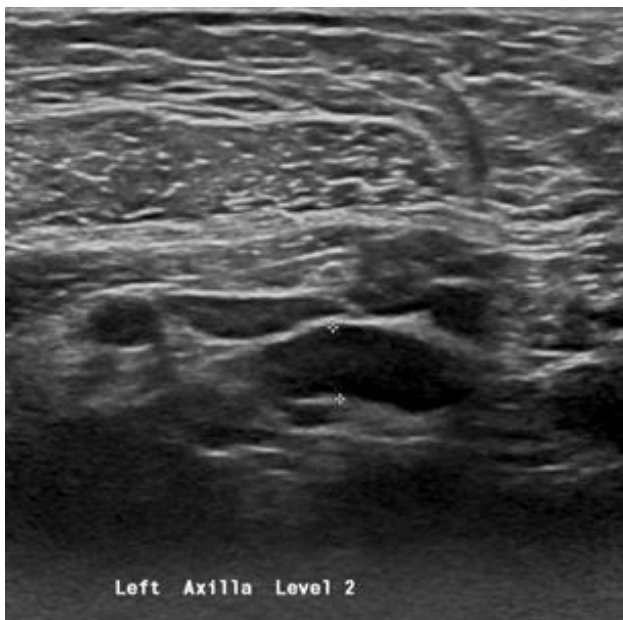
a,b Ultrasound axilla showing two abnormal axillary lymph node. In image a, it is at level 2 and has diffuse cortical thickening. Image 2B, the lymph node is at level I. It is irregular nodular cortical thickening and is very hypoechoic with indistinct medial border
